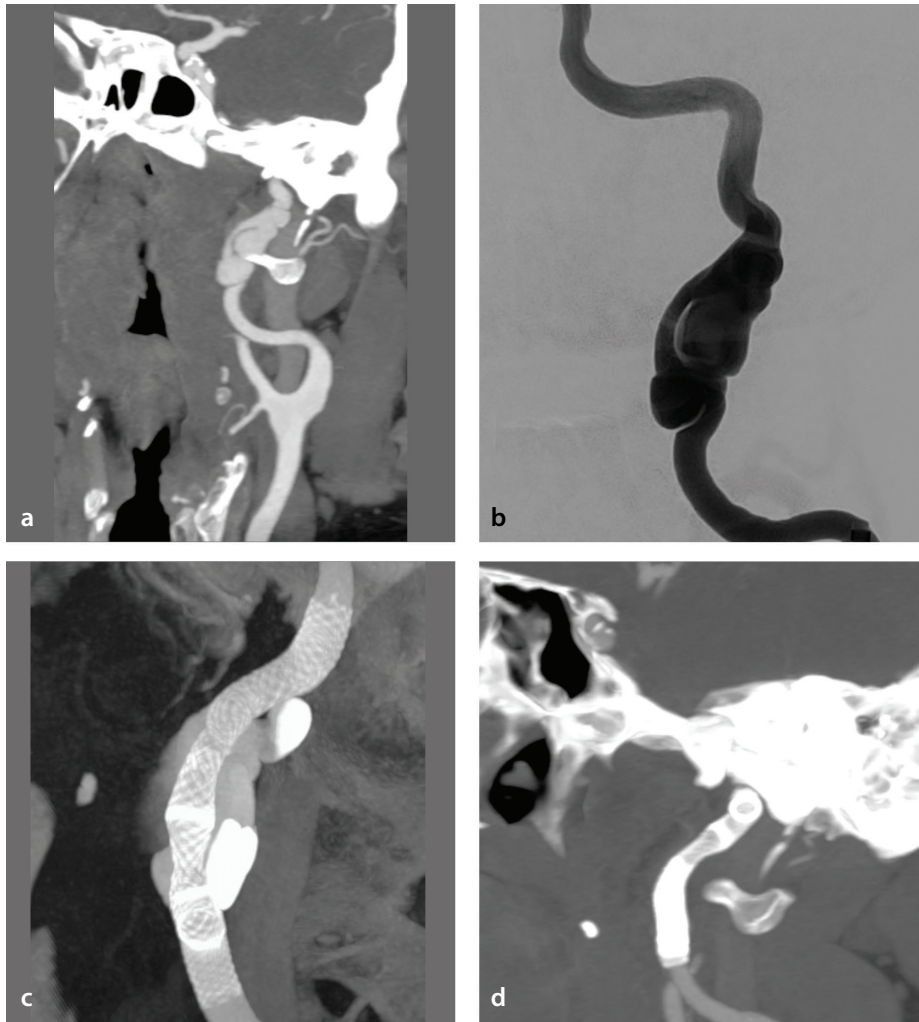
Patient 8: Chronic dissecting aneurysms in the high-cervical segment of the left internal carotid artery. Computed tomography (CT) angiography (a) and digital subtraction angiography (b). (c) Cone-beam CT after telescopic flow-diverting stent implantation in the dissected segment. (d) Twenty-four-month control CT angiography confirms aneurysm occlusion and the reconstruction of the dissected segment.
